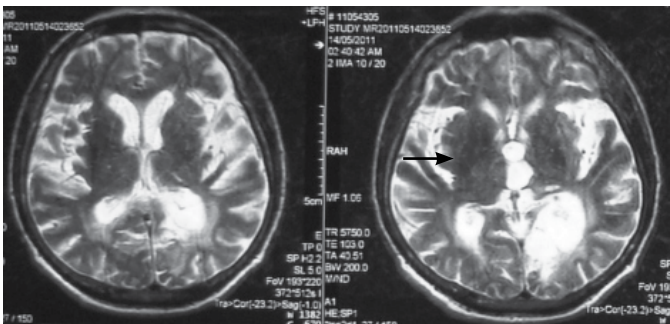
Marked bilateral hypointense appearance in the right putaminal region (arrow) on T2-weighted MR sections
